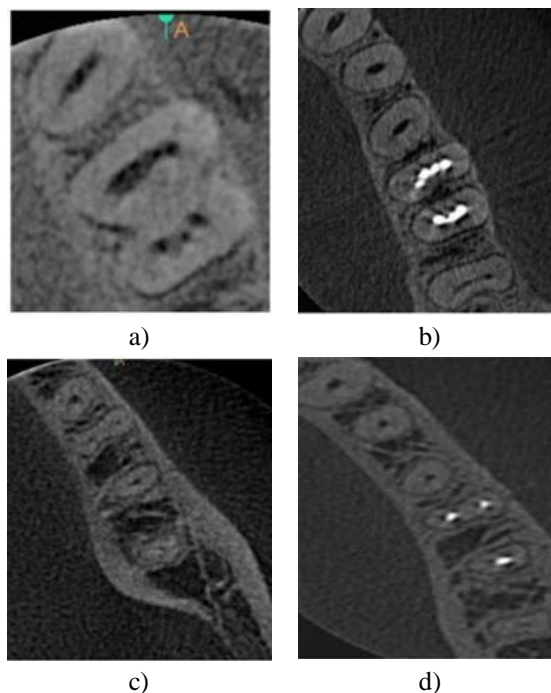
a) pre-operative coronal CBCT image showing the presence of seven canals, b) post-operative coronal CBCT image showing the presence of seven canals, c) pre-operative axial CBCT image showing the presence of seven canals, and d) postoperative axial CBCT image showing the presence of seven canals.
